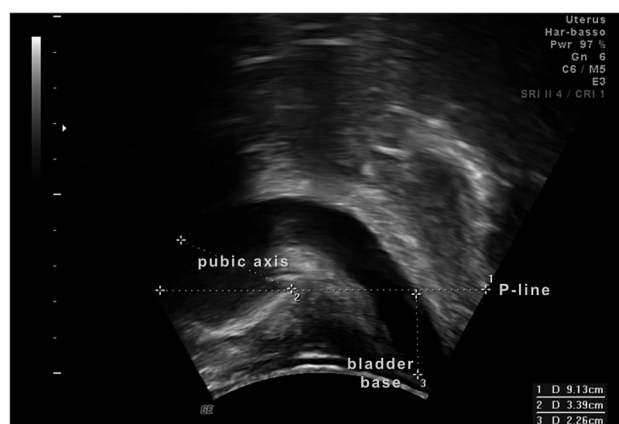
Distance between bladder base and P-line under stress: ultrasound stage IV ($D_3 = -23$ mm).
